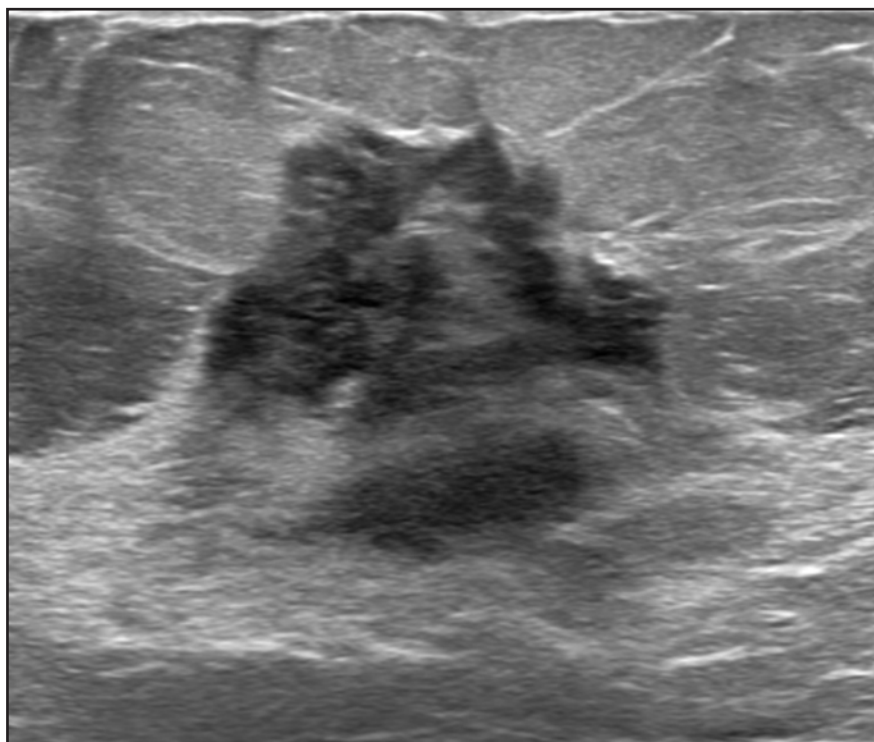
Right breast targeted B-mode grayscale ultrasound image in the transverse plane demonstrates an irregular mass at 12 o'clock in the subareolar location.
